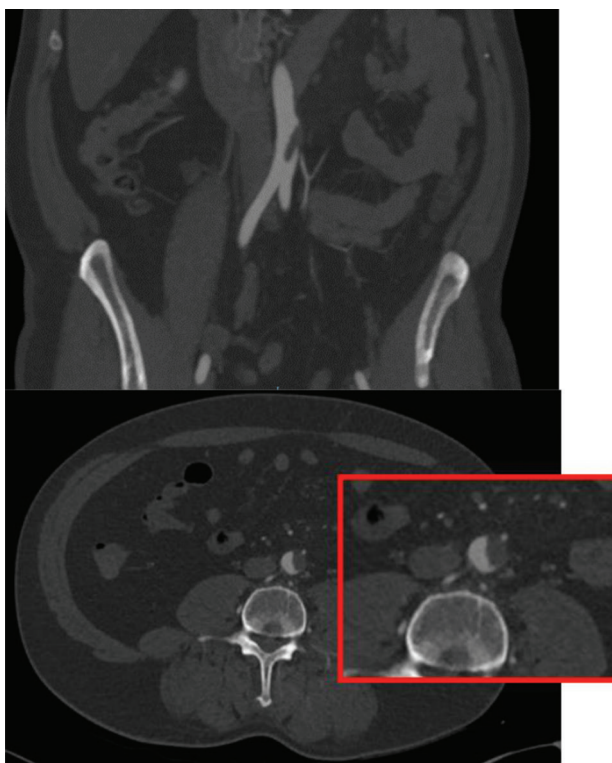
CT angiography images of the patient in case 2.
